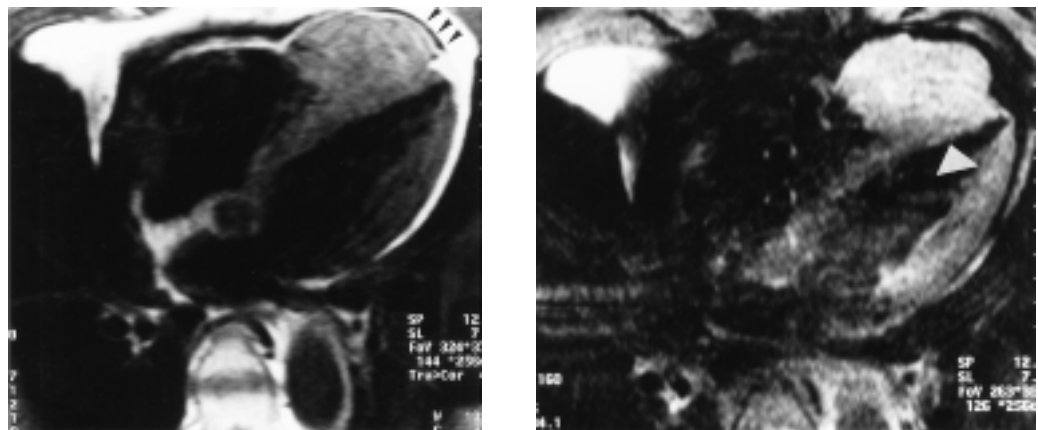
Nuclear magnetic resonance imaging, long-axis section of the cardiac chambers. Left panel: in the T1 sequence, the intensity of the signal of the tumor mass (arrowheads) is similar to that of the myocardium. Right panel: in the weighed T2 sequence the mass appears hyperintense. The interventricular septum also appears thickened (arrowhead), possibly due to tumor infiltration.
